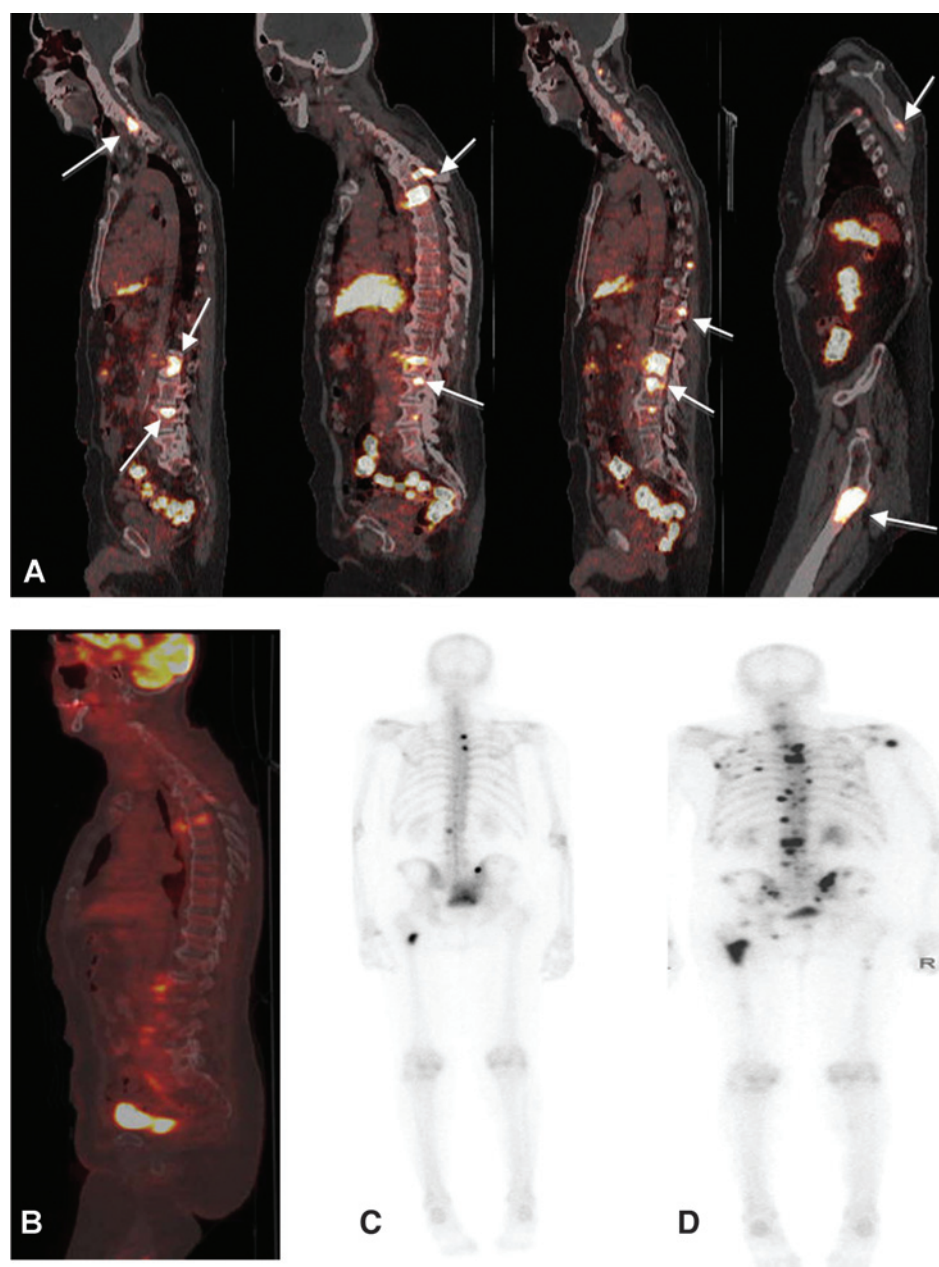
Patient with metastatic prostate cancer (PSA 90.9) with ^{89}Zr -J591-positive lesions that were not seen on MDP. Follow-up imaging showed POD on MDP. ^{89}Zr -J591 scan (A) showed uptake in multiple bone sites (arrows) that were not seen on concurrent FDG scan (B) or bone scan (C). A follow-up bone scan (D) showed uptake in the sites and was consistent with POD.
